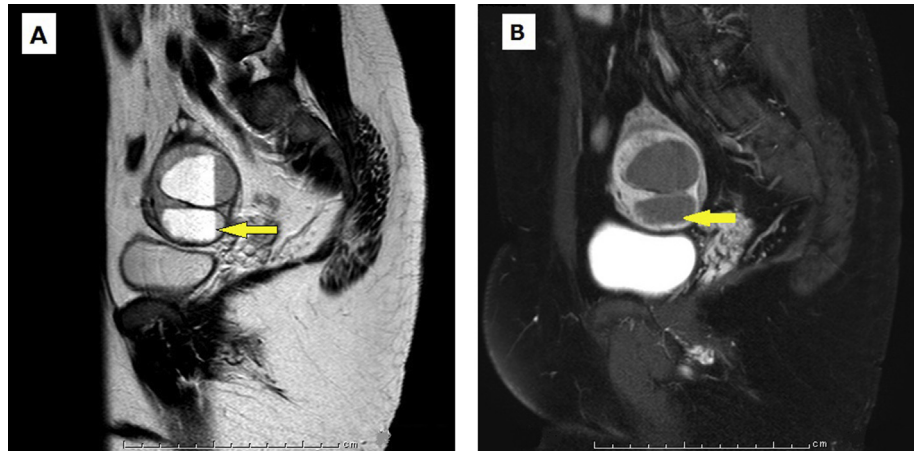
Magnetic resonance imaging. (A) T2-weighted imaging showing a double cystic left ovarian tumor with high-signal-intensity appearance and fluid–fluid level (arrow). (B) T1-weighted imaging showing iso-signal intensity (arrow) in which a bloody fluid component was indicated. There was neither solid component nor contrast enhancement.
